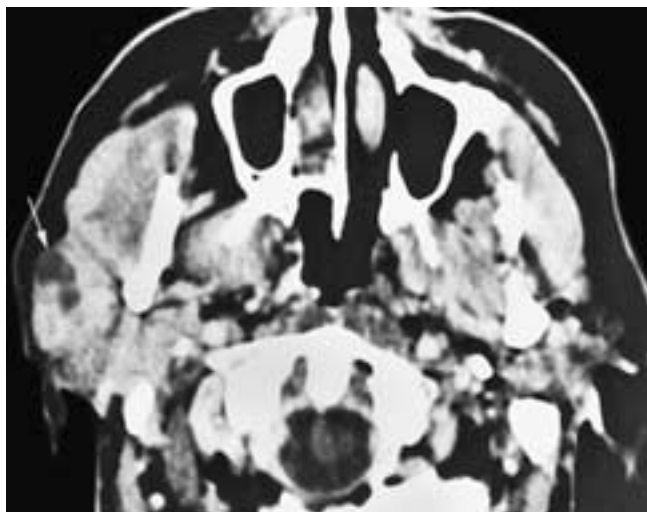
Axial contrast-enhanced CT scan shows several small cysts in the anterior superficial portion of the right parotid gland (*arrow*). The right parotid gland is denser than normal. These were posttraumatic acquired cysts.
